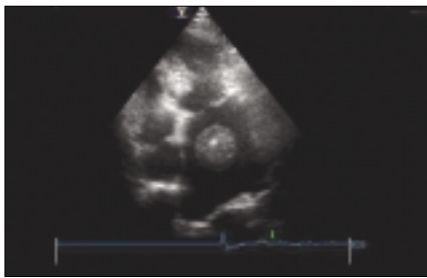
Site of the attachment of the left atrial mass is not clearly identified by transthoracic echocardiography
